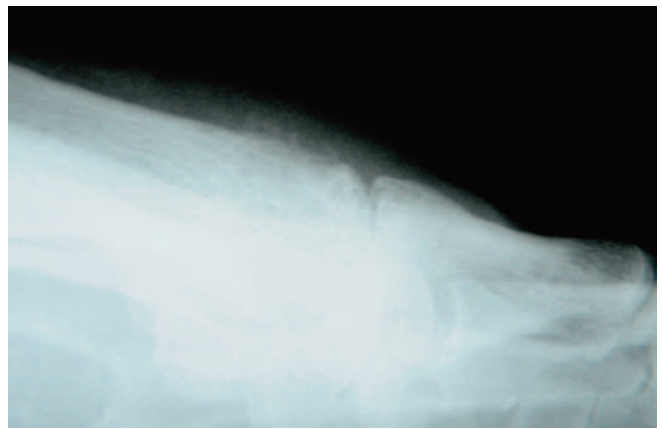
Case Study 1. Postoperative lateral radiograph.
